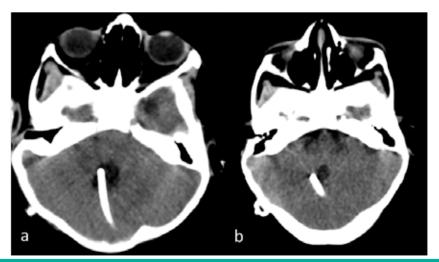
a) Brain CT performed after fourth ventricle shunting revealing that the size of the fourth ventricle had significantly diminished; b) Brain CT performed 57 months after fourth ventricle shunting revealing normal-sized fourth ventricle.
